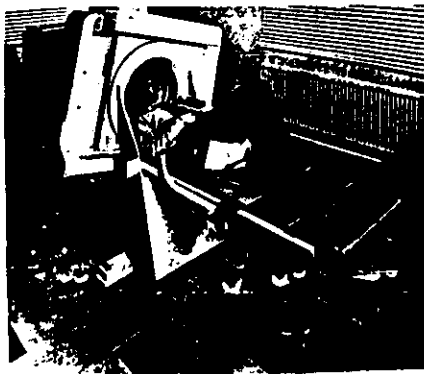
First clinical CT-scanner installed at the A.Morley's hospital in Wimbledon.
